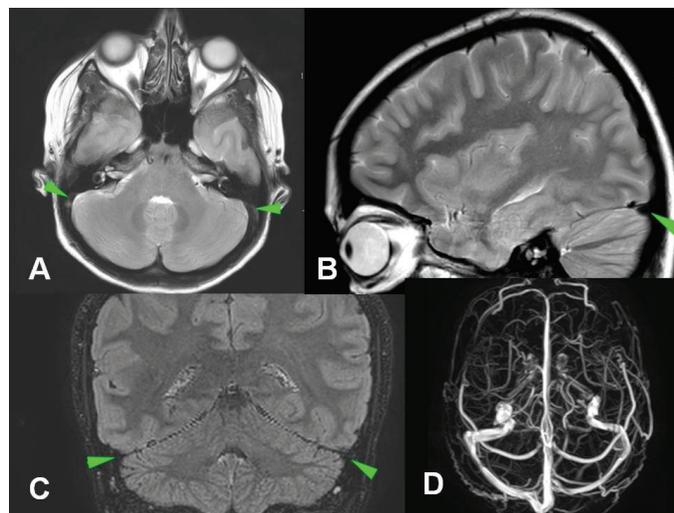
Magnetic resonance imaging after anti-TNF (A-D) of a 21-year-old female patient with dural venous sinus thrombosis diagnosed with Behçet's. Axial T2-weighted MR (A), sagittal T2-weighted MR (B), and coronal FLAIR (C) images show no thrombus in bilateral transverse sinuses (arrowhead). A magnetic resonance venography (D) shows no thrombus in bilateral transverse sinuses (arrow) and sigmoid sinuses (arrowhead)
